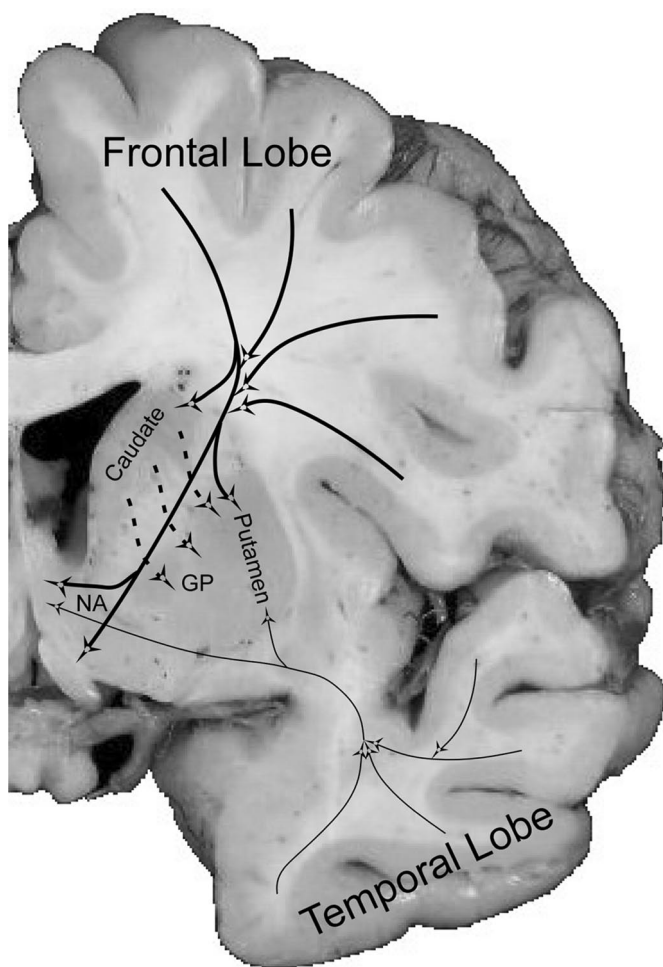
Coronal section of an MRI scan of the anterior internal capsule. Frontal projections (to the thalamus, striatum, anterior commissure, and cerebral peduncle) are shown as thick solid lines. Temporal projections (to the striatum and the contralateral limbic system) are shown as thin solid lines. Projections of the caudate (to the lenticular nuclei) are shown as thick dashed lines. GP, globus pallidus; NA, nucleus accumbens.
